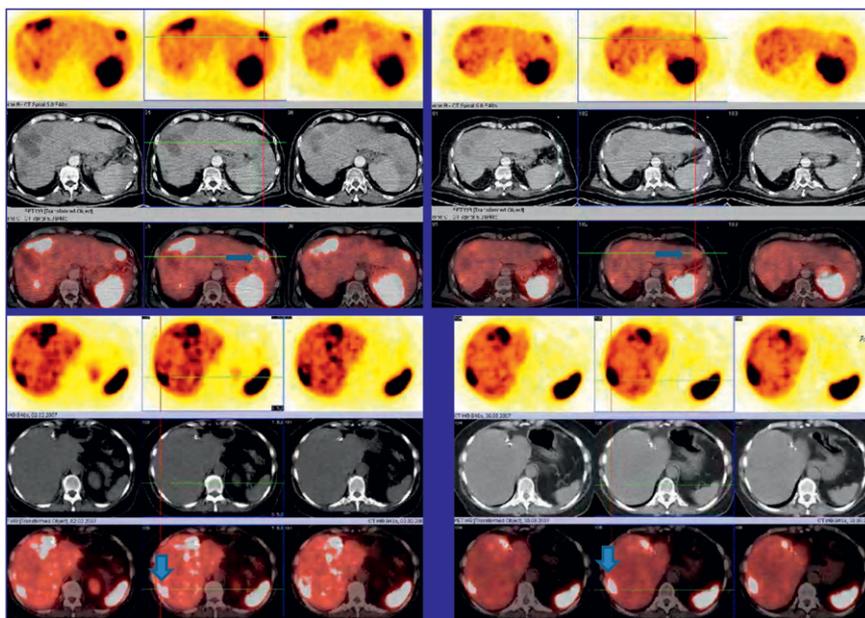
^{68}Ga -DOTATOC PET/CT imaging before (left) and after (right) peptide-receptor radiotherapy in a responder (top; 42% reduction in SUV_{max} ; 371 Gy dose to tumor) and nonresponder (bottom; 125% increase in SUV_{max} ; 25 Gy dose to tumor).
